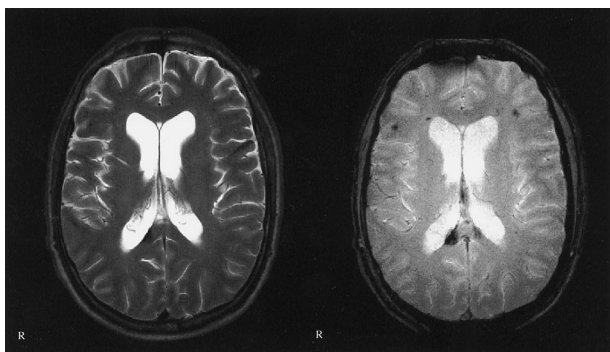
Images of a 42-year-old man who was a passenger in a traffic accident in September 2000. Traumatic microbleeds are shown in the posterior corpus callosum. *Left*, T2-weighted image; *right*, T2*-weighted image. Note the additional traumatic microbleeds in the left side of the splenium and at the gray matter-white matter border of the frontal lobes, which are not visible on the T2-weighted images. No T2-hyperintense callosal lesions are seen. GCS score, 3; GOS score, 4.
